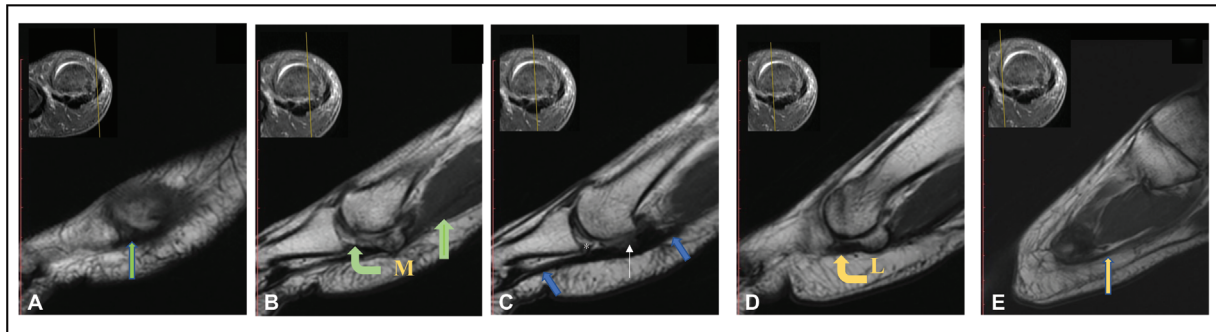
Plantar plate complex. The serial sagittal T2-weighted magnetic resonance images show the components of the plantar plate complex of the first metatarsal joint with corresponding level of section (shown in the inset). (A) The medial most section shows attachment of the abductor hallucis (green arrow) to the medial sesamoid and capsuloligamentous structures attaching to the medial side of the base of the first metatarsal. (B) The next section shows medial sesamoidophalangeal ligament (SPL; bent green arrow) between the medial sesamoid (M) and plantar surface of the base of the base of the first proximal phalanx and the medial head of flexor hallucis brevis (FHB) attaching to the medial sesamoid (M). (C) The section through the midline of the metatarsophalangeal (MTP) joint, shows the flexor hallucis longus (FHL) tendon (blue arrows) passing over the fibrocartilage part of the plantar plate (white asterisk) and inseparable from the intersesamoid ligament (thin white arrow). (D) The sagittal section at the level of the lateral sesamoid (L) shows the lateral SPL (bent yellow arrow) between the lateral sesamoid (L) and plantar surface of the base of the base of the first proximal phalanx and the lateral head of FHB attaching to lateral sesamoid (L). (E) The lateral most section through the first MTP joint shows the conjoint tendon of adductor hallucis (yellow arrow) attaching to the lateral sesamoid, adjacent capsuloligamentous complex, and lateral surface of the base of proximal phalanx.
